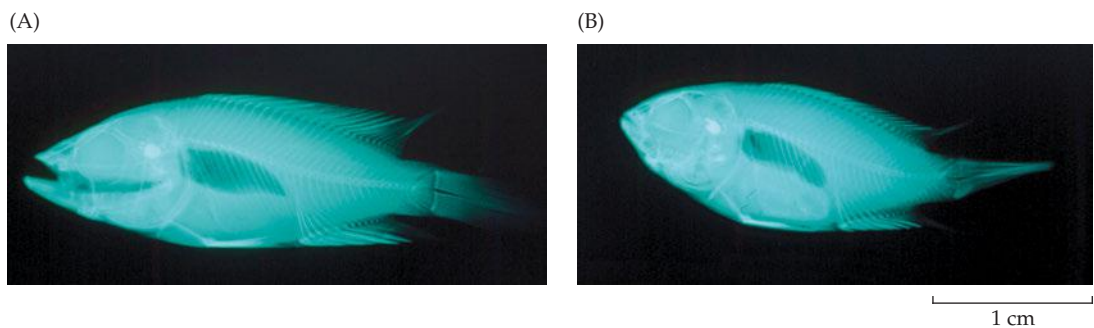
X-rays of cichlid fish fed different diets for 8 months. (A) Fish fed shrimp larvae developed a narrow-angled jaw. (B) Fish fed commercial flaked food and nematodes had a wider-angled jaw. (From Meyer 1987, photographs courtesy of Axel Meyer.)
